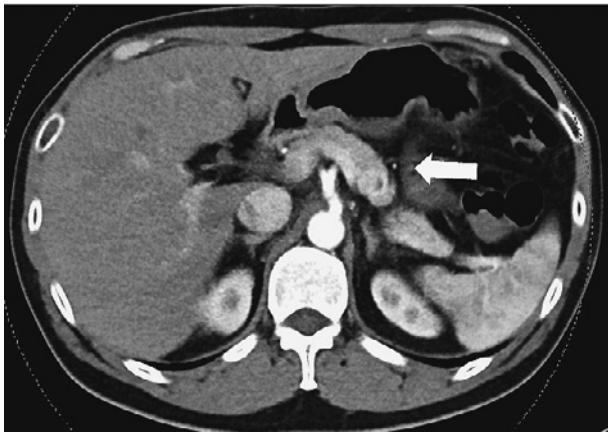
Enhanced computed tomography revealed 20 mm of mass at the tail of pancreas.
